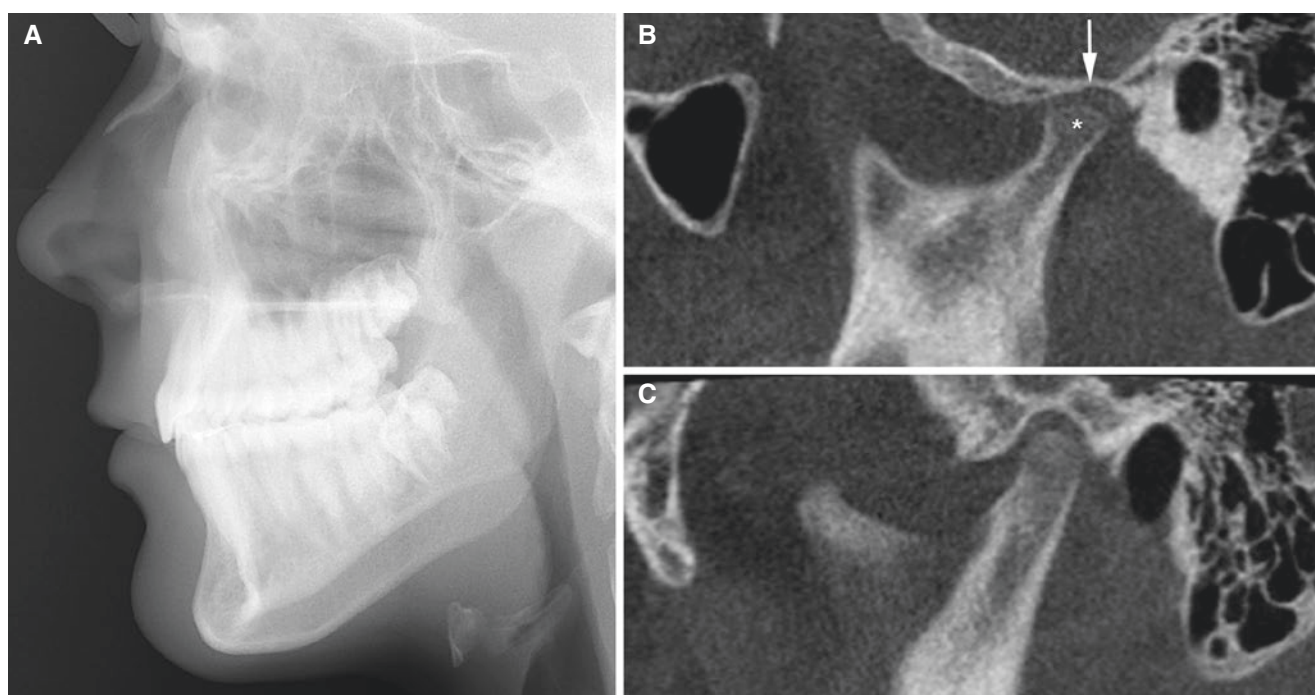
Juvenile idiopathic arthritis; 15-year-old female with facial asymmetry but no symptoms or other clinical signs. (A) Lateral cephalogram shows asymmetric mandibular growth (due to unilateral TMJ involvement), but normal facial profile. (B) Oblique sagittal CBCT
